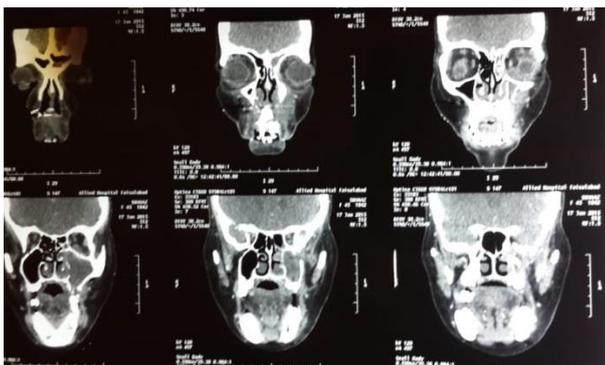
Computed tomography scan showing involvement of left maxillary sinus and nasal cavity
